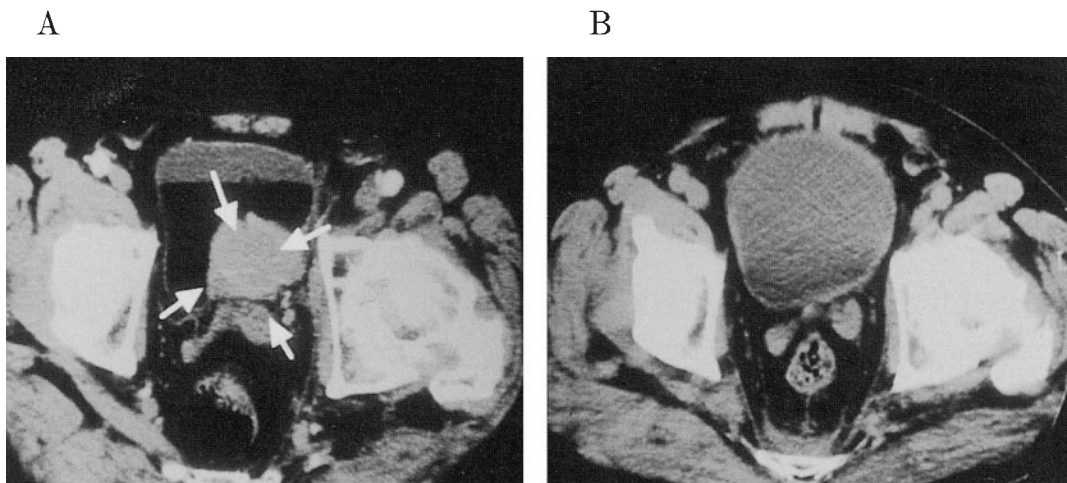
Pelvic computed tomography of case no. 7.
